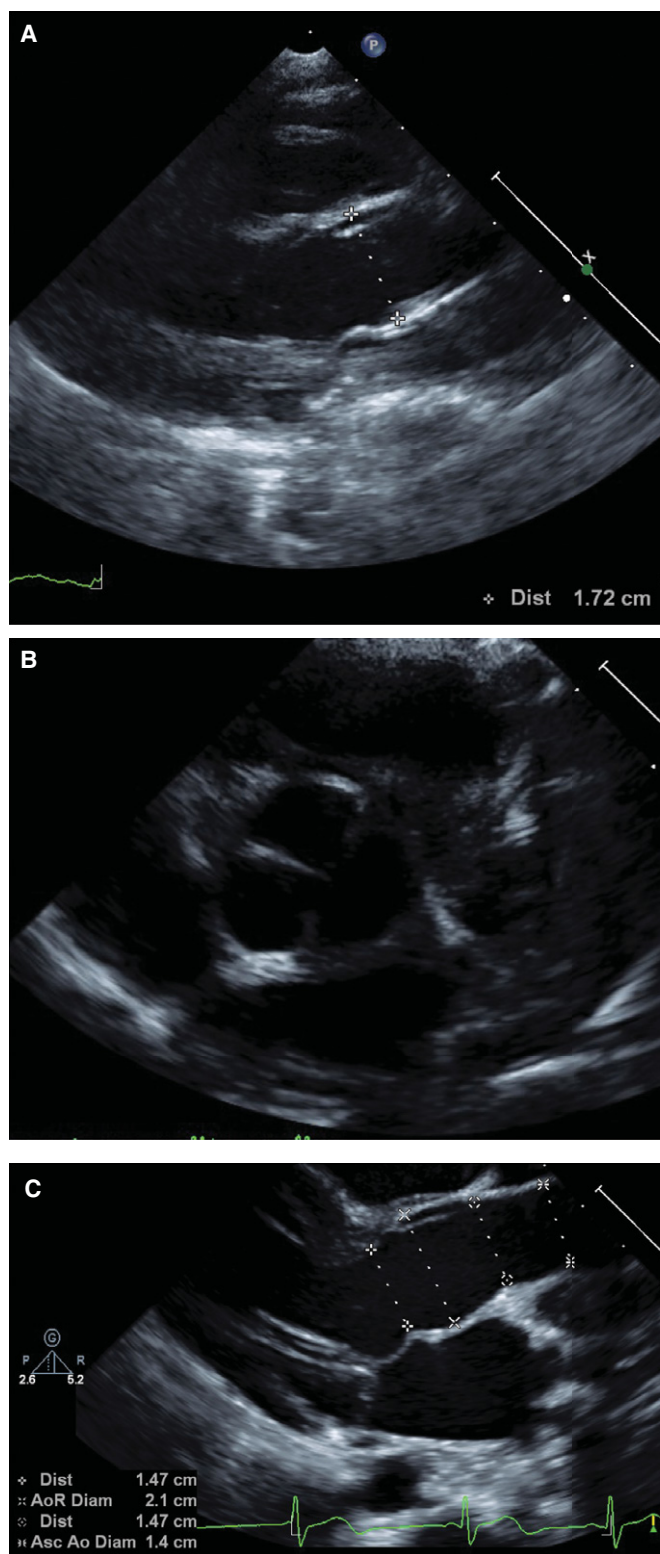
Echocardiogram images. (A) Aortic root at 17 mo, before Undiagnosed Diseases Network (UDN) evaluation. (B) Trileaflet aortic valve at 17 mo. (C) Aortic root at 4 yr and 3 mo.
